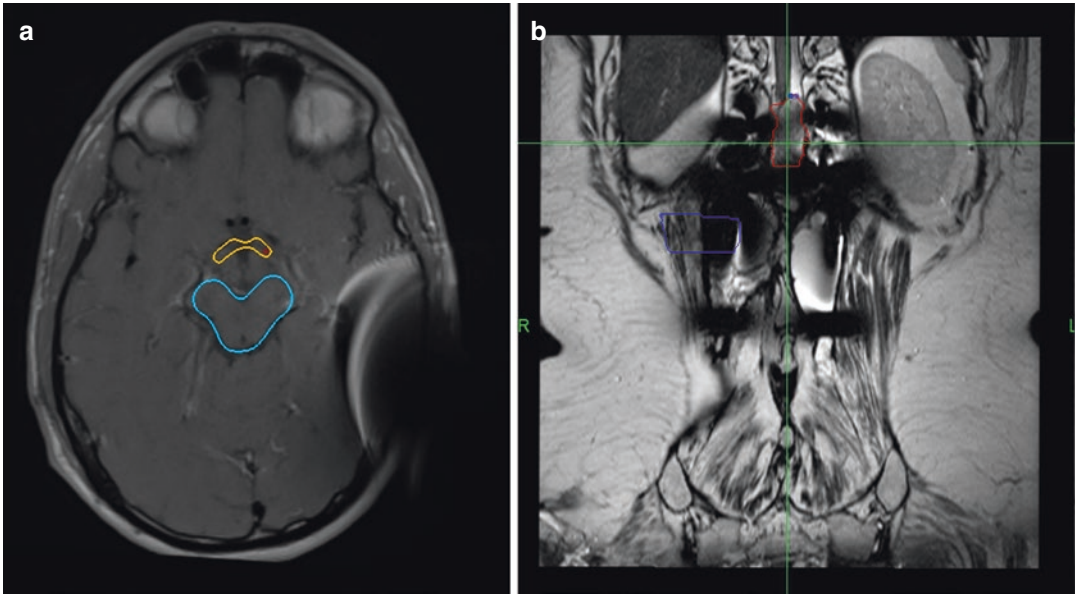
(a) Axial MR image of a patient with a CSF pump resulting in an artifact obscuring part of the brain parenchyma. (b) A spine case with the target indicated by
